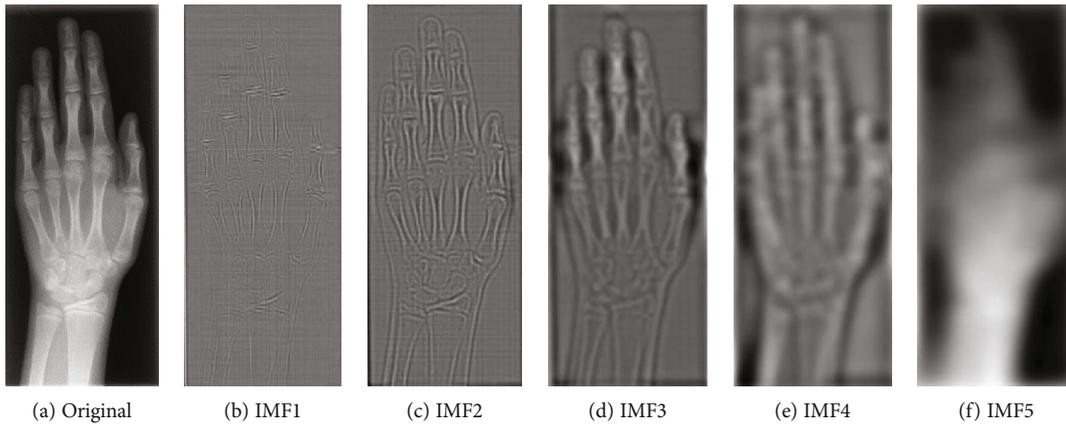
An example of a medical X-ray image is decomposed into five IMFs using empirical mode decomposition.
